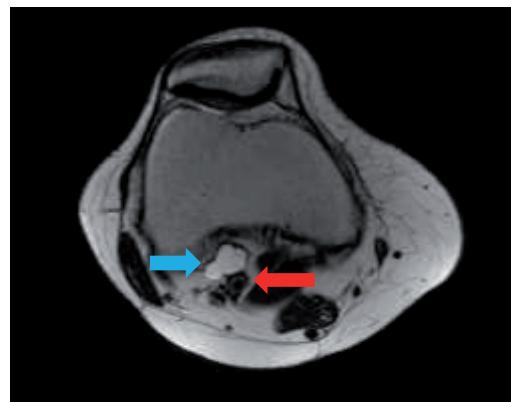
(A) MRI showing cystic formation (blue arrow) in close contact with the popliteal artery (red arrow).
